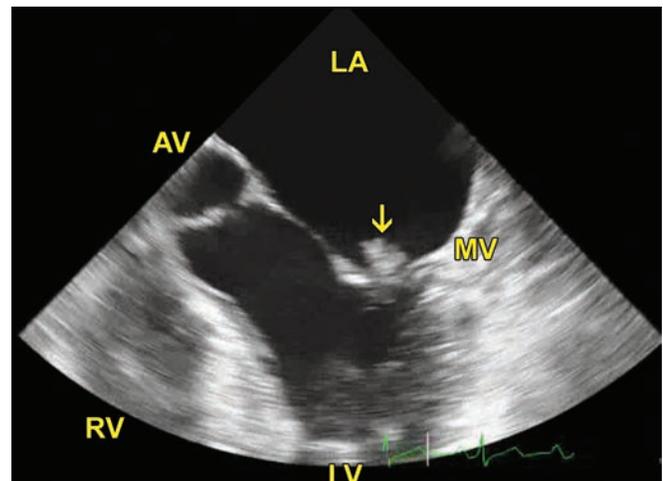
Transesophageal echocardiogram at mid esophagus level. Notice the mass attached to the mitral valve (arrow).
